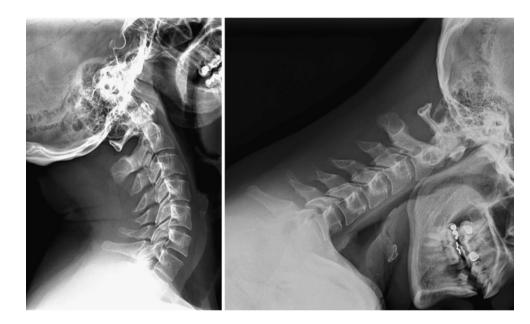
Dynamic X-ray showing persisting motion at C6-C7 level
